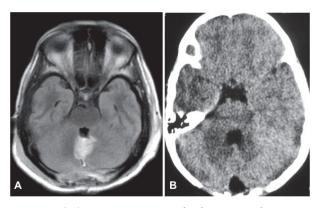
3A: Post operative Fluid Attenuated inversion recovery (FLAIR) MRI done on 10th post operative day showing well decompressed pontine epidermoid cyst.
